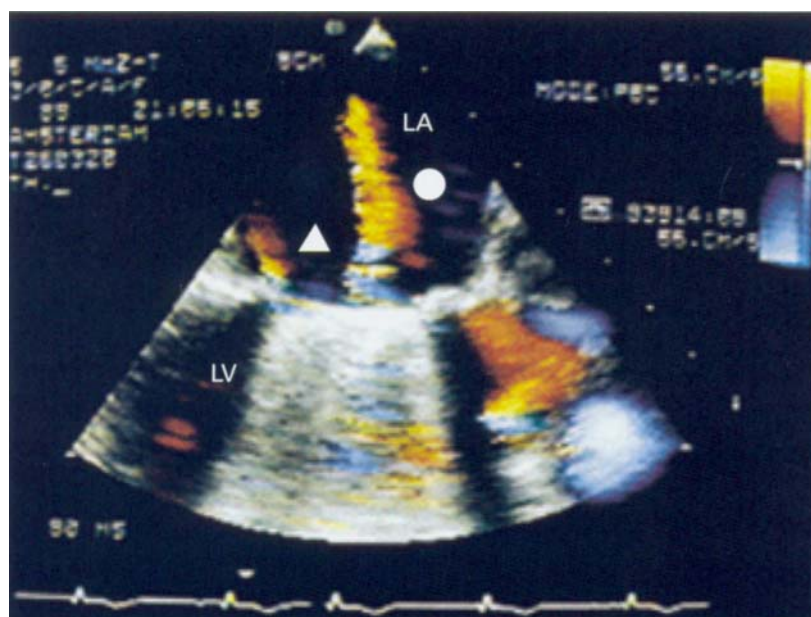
Transoesophageal echocardiographic colour Doppler flow image from a patient with a normal Medtronic Hall prosthesis in the mitral position. The white circle indicates an apparent central jet starting after valve closure. One of the two small peripheral jets is also visualized in this plane (triangle). LA = left atrium, LV = left ventricle. (Reproduced from Van den Brink *et al.* 1989,¹⁰ with permission from Excerpta Medica Inc., and the first author.)
